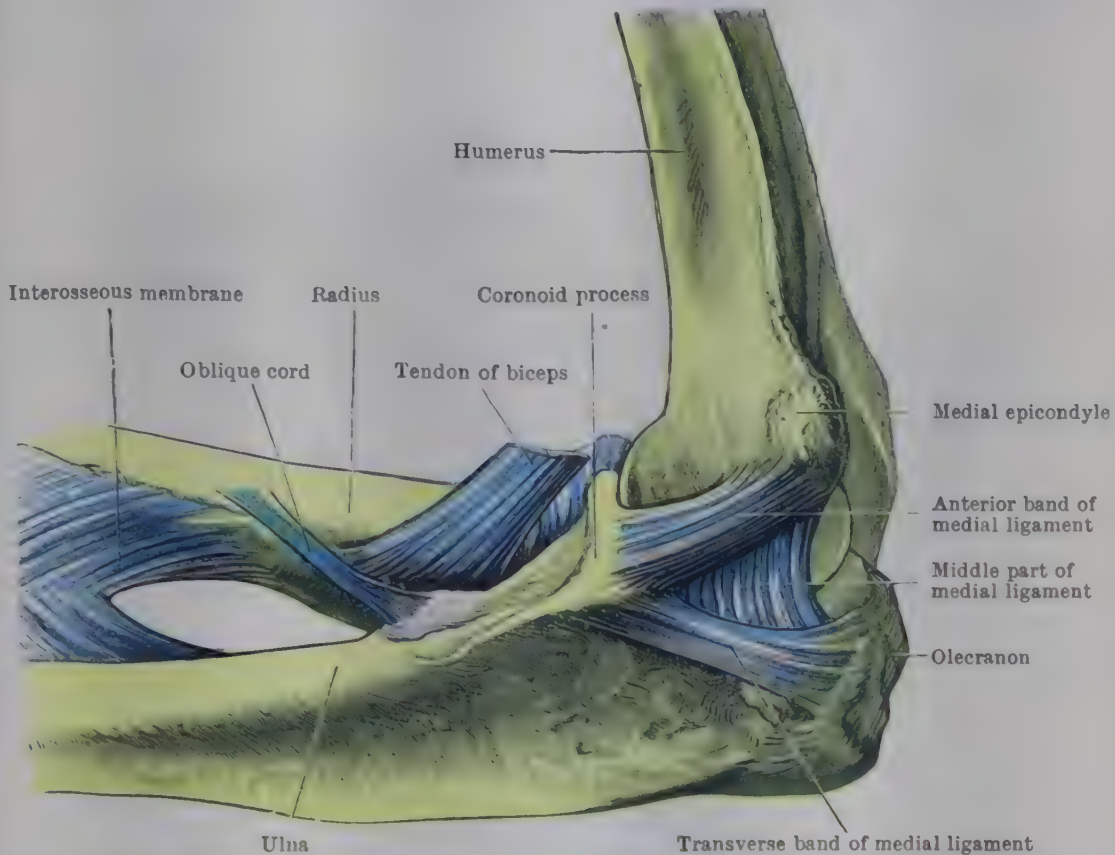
MEDIAL ASPECT OF DISSECTION OF ELBOW JOINT, WITH ANTERIOR AND POSTERIOR LIGAMENTS REMOVED.
